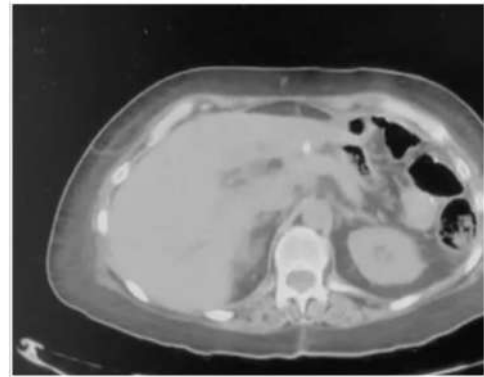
CT after completion of endoscopic vacuum therapy showing no signs of liver abscess.
